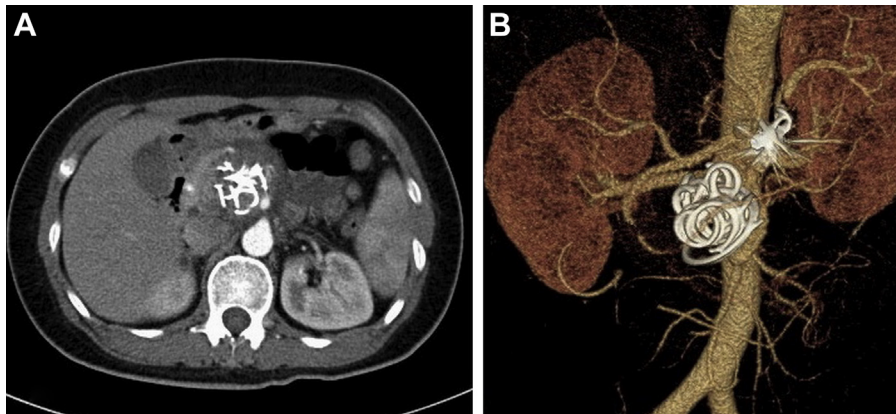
A, A computed tomography angiogram (CTA) 1 year postoperatively confirms occlusion of the anomalous splenic artery (SA) aneurysm (SAA). Coils are visible in the outflow vessel and in the aneurysm sac. B, A three-dimensional reconstruction transverse image of the CTA shows expected sac shrinkage and no evidence of splenic infarction.
